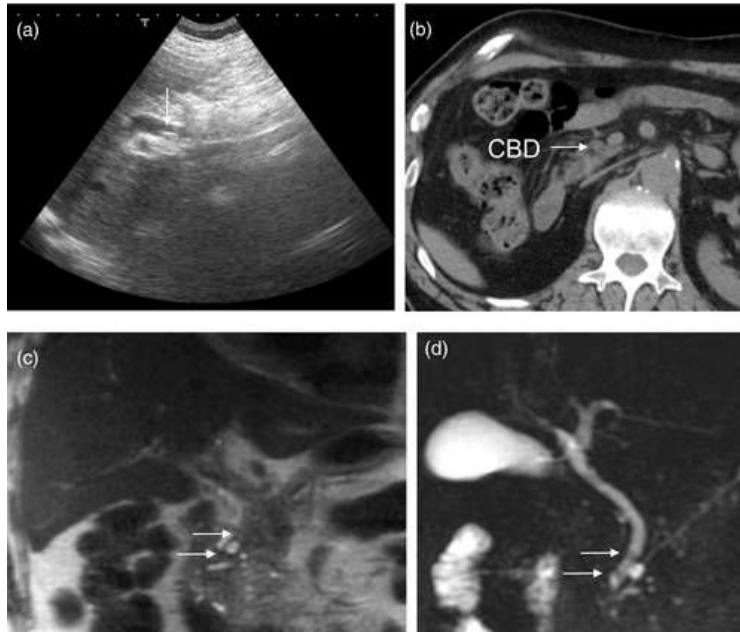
Bile duct stones. (a) Abdominal ultrasound, (b) non-contrast CT scan, (c) coronal T2-weighted MRI, and (d) MRCP image. (Kiriya et al, 2018)
